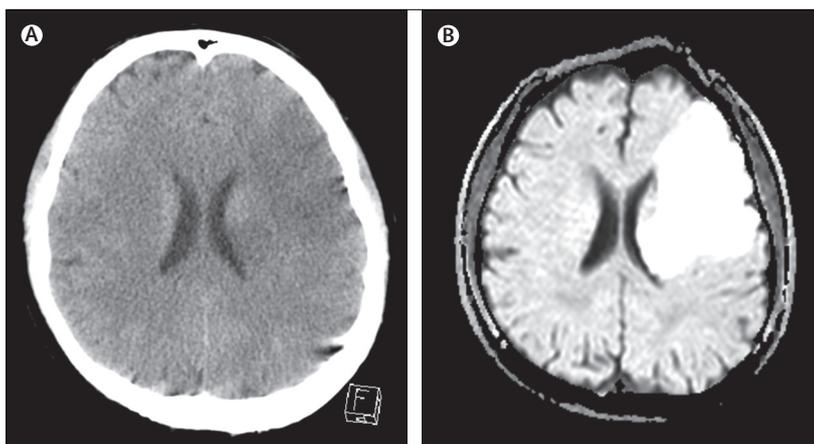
Imaging of large middle cerebral artery cardioembolic stroke in a patient with atrial fibrillation (A) CT and (B) subsequent MRI from a 39-year-old man with large middle cerebral artery cardioembolic stroke.
